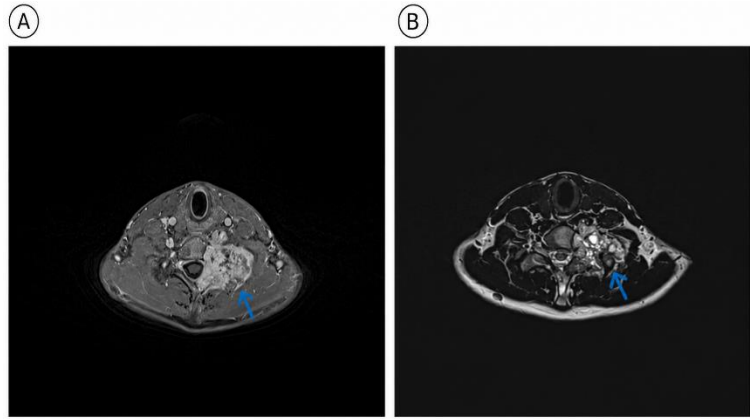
MRI of the cervical spine with IV gadolinium (A) and T2WI (B) revealed a well-defined expansile vertebral mass involving part of the vertebral body and left-sided posterior vertebral elements (Blue arrow), showing a T2 intermediate-signal-intensity solid enhancing component peripherally and a multiloculated central cystic change.
